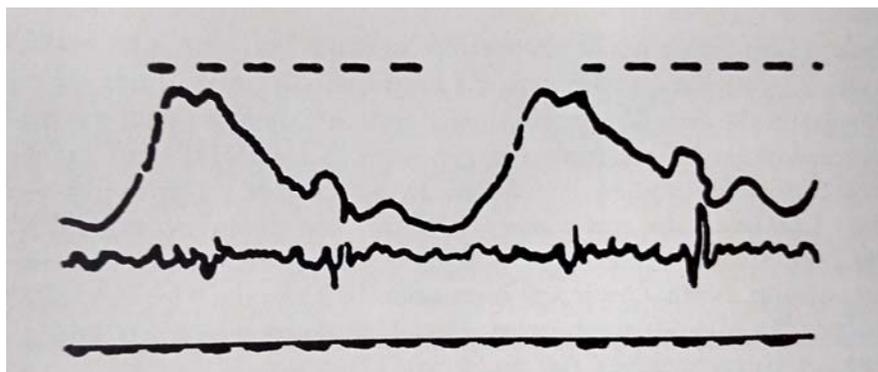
Keidel’s ultrasound cardiogram by transmission (upper trace). The lower trace shows the heart sounds. (1950). [101]
